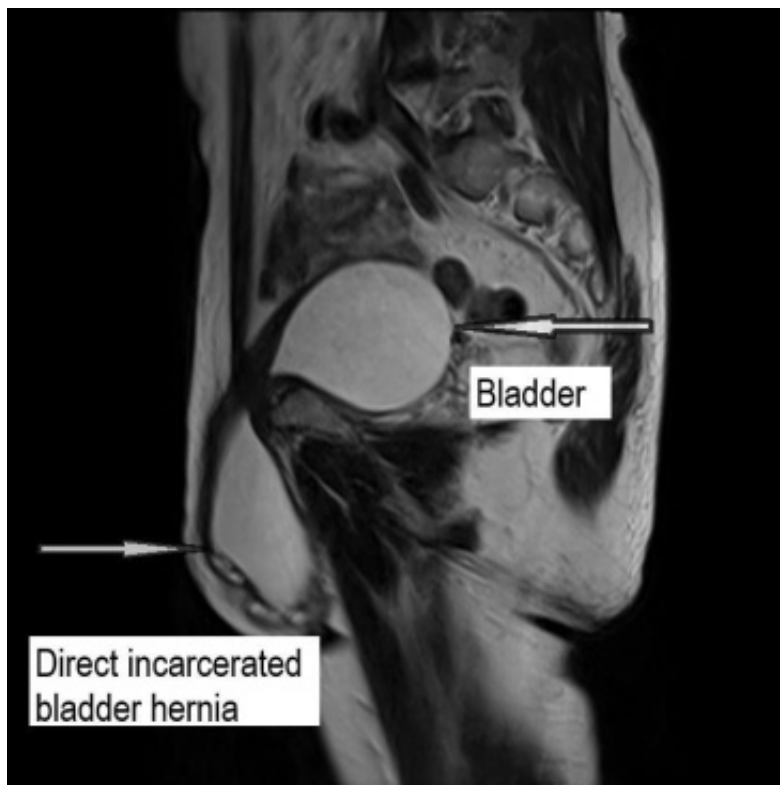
Magnetic resonance image of incarcerated bladder hernia
